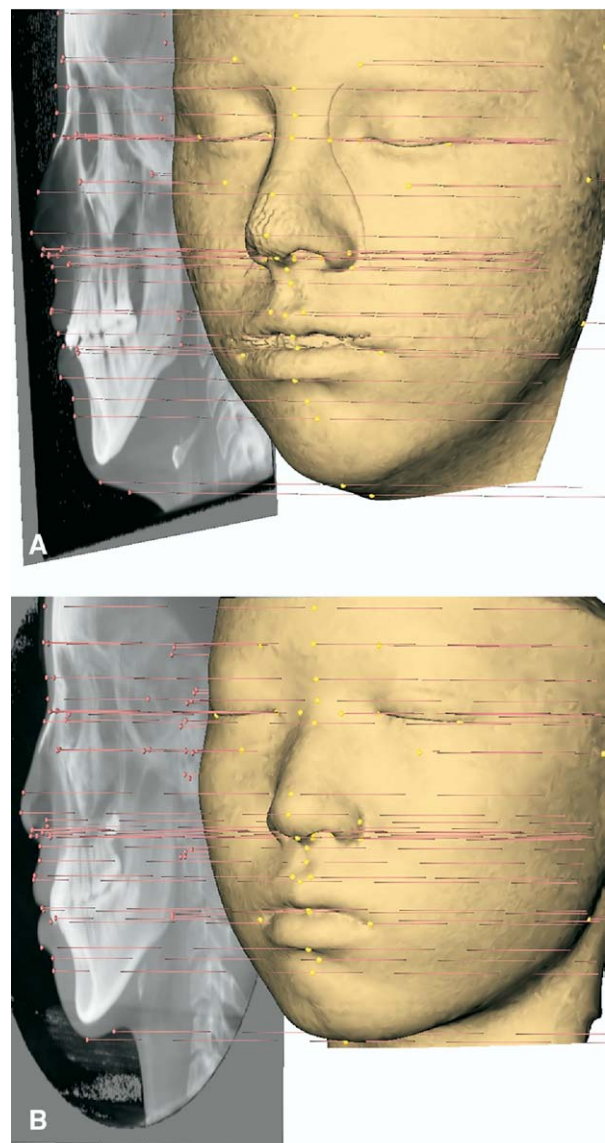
Virtual lateral cephalograms linked to 3D soft-tissue surface representations with setup of 3D cephalometric soft-tissue landmarks: A, i-CAT and B, Hitachi CBCT.
